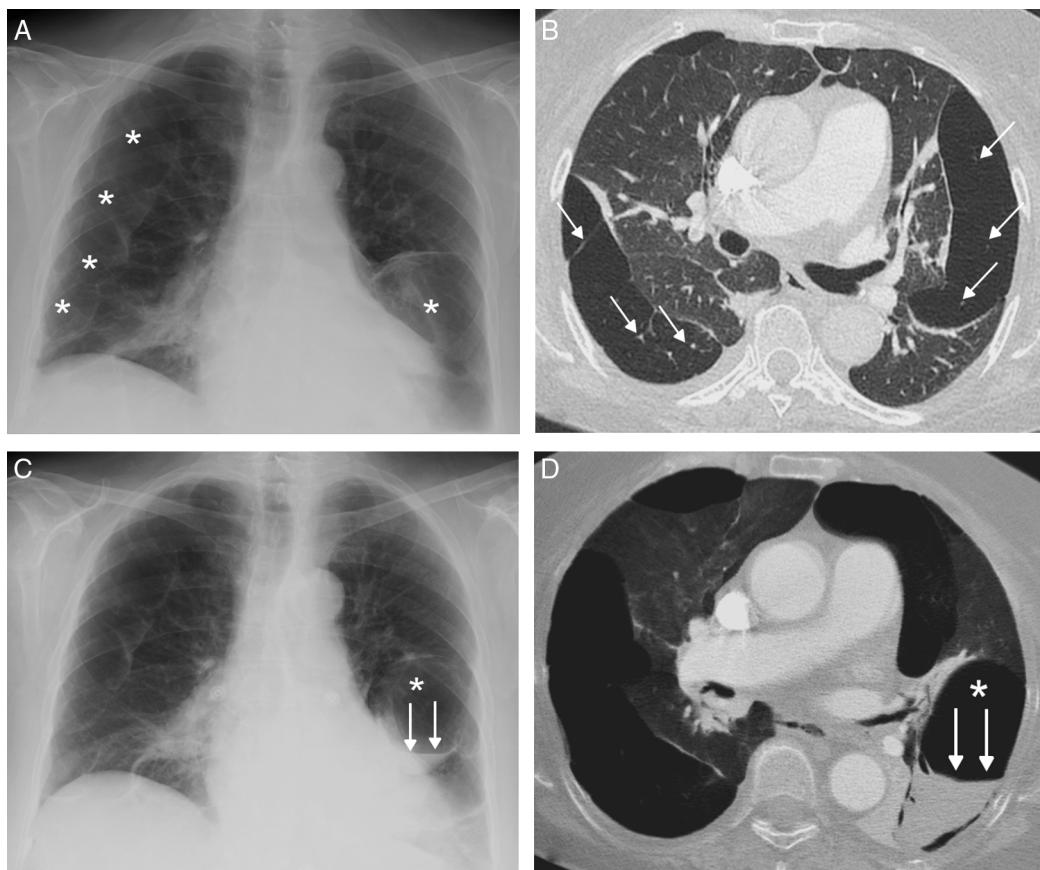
(A) Chest radiograph, showing multiple subpleural cystic formations (asterisks) in both lungs. (B) Axial image of chest CT (lung window), showing multiple converging cystic lesions in the periphery of both lungs. Note the presence of small pulmonary vessels (arrows) traversing the cystic formations. (C) Chest radiograph identifying an air-fluid level (arrows) in a cystic lesion in the left lung base (asterisk). (D) Minimum intensity projection (minIP) axial reconstruction, showing the air-fluid level (arrows) corresponding to bleeding in the interior of a cystic lesion (asterisk) in the left lower lobe.
